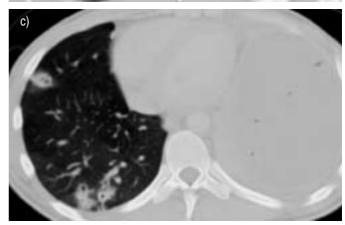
Computed tomography scans from 2003 showing a) slightly larger right upper lobe, b) correspondent lesions, and c) new loculated left pleural effusion and more prominent lesions on the right, also with (pseudo)cavitation.
